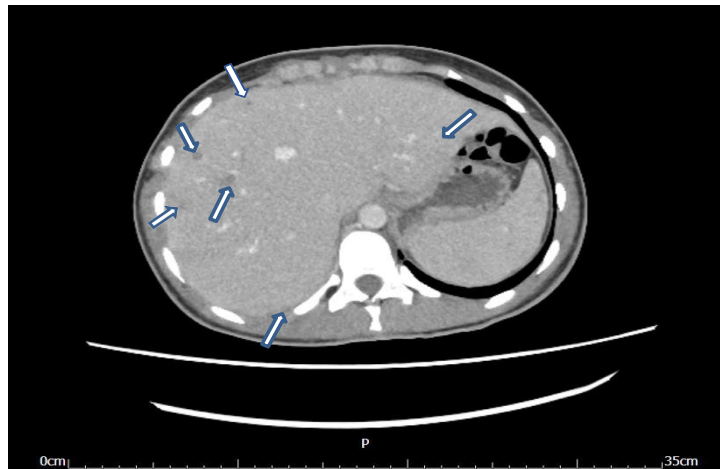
CT abdomen showing multiple miliary nodules (tubercules) indicated by the white arrows.
